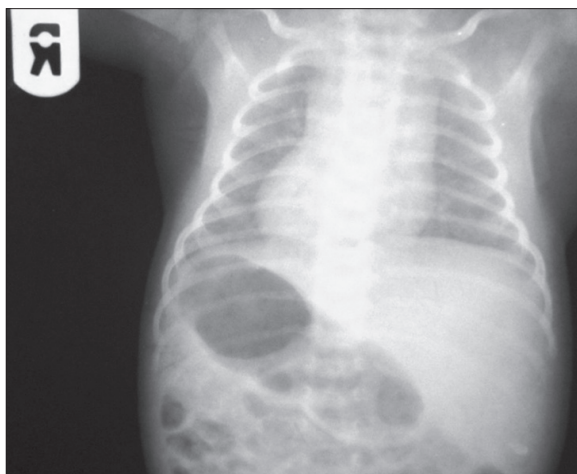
Chest X-ray of case 2 showing dextrocardia, the gastric bubble on the right side and the liver on the left side
